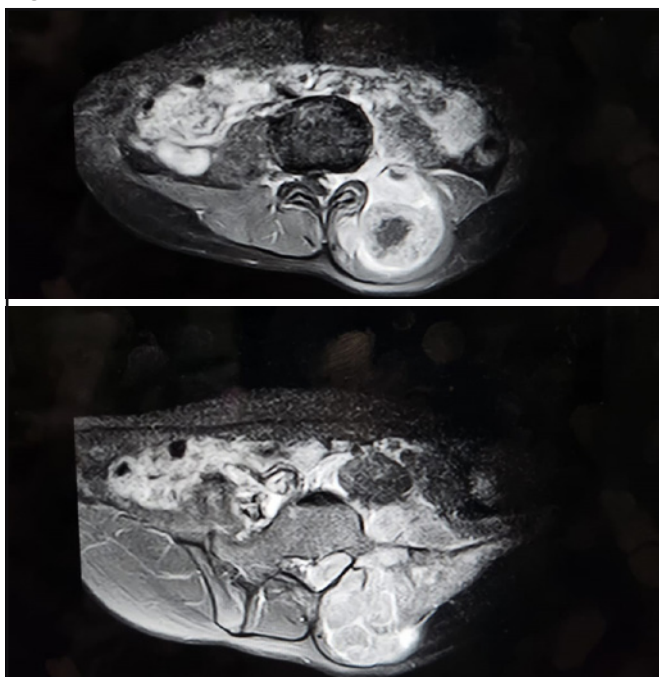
MRI post contrast axial cuts show heterogeneous post-contrast enhancement.
